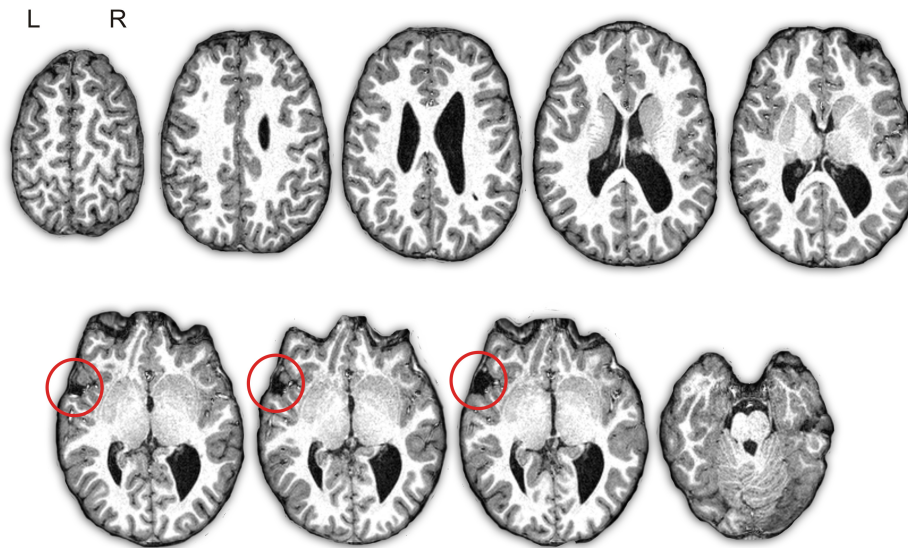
Depiction of subject D's structural T1-weighted images. Axial slices of the brain in native space show the asymmetry of the volume of the lateral ventricles (right > left) with right occipital colpocephaly. There is an "open operculum sign" in the left hemisphere due to arrested development of the inferior frontal gyrus and superior temporal gyrus with exposure of the insular cortex (red circle). L, left; R, right.
